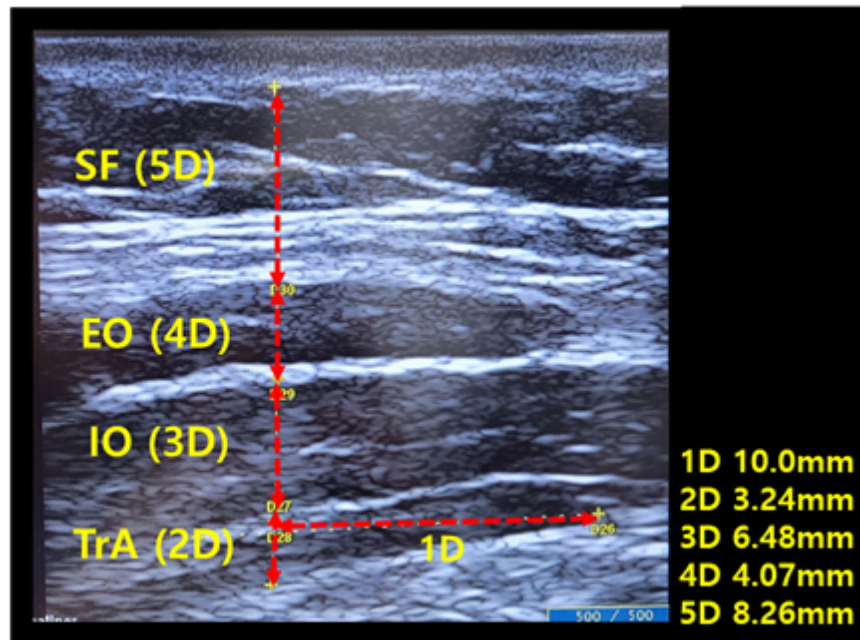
Real-time ultrasound imaging measures (TrA, transverse abdominis; IO, internal abdominal oblique; EO, external abdominal oblique; SF, subcutaneous fat)
